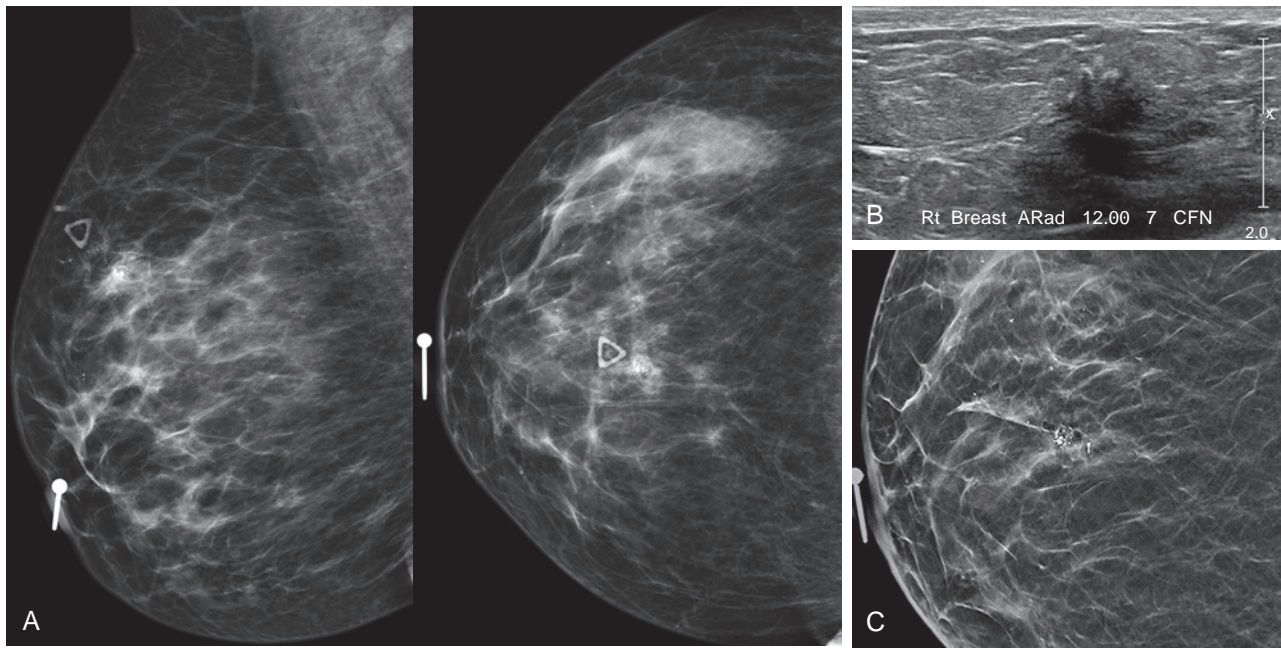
(A) A 41-year-old woman presented to an outside facility with a palpable hard mass in an area of prior skin piercing (ornament since removed). Two-dimensional mammographic views demonstrate a focal asymmetry with an indistinct margin containing heterogeneous clustered calcifications. (B) A targeted ultrasound reveals an irregular hypoechoic mass with dense posterior acoustic shadowing and internal echogenic foci. The lesion was described as highly suggestive of malignancy, and an ultrasound-guided biopsy was performed revealing fat necrosis. (C) Tomosynthesis views performed at our institution showed biopsy clip in a fat-containing lesion with peripheral distribution of “egg-shell” calcifications, consistent with fat necrosis, and thus biopsy was not necessary.
